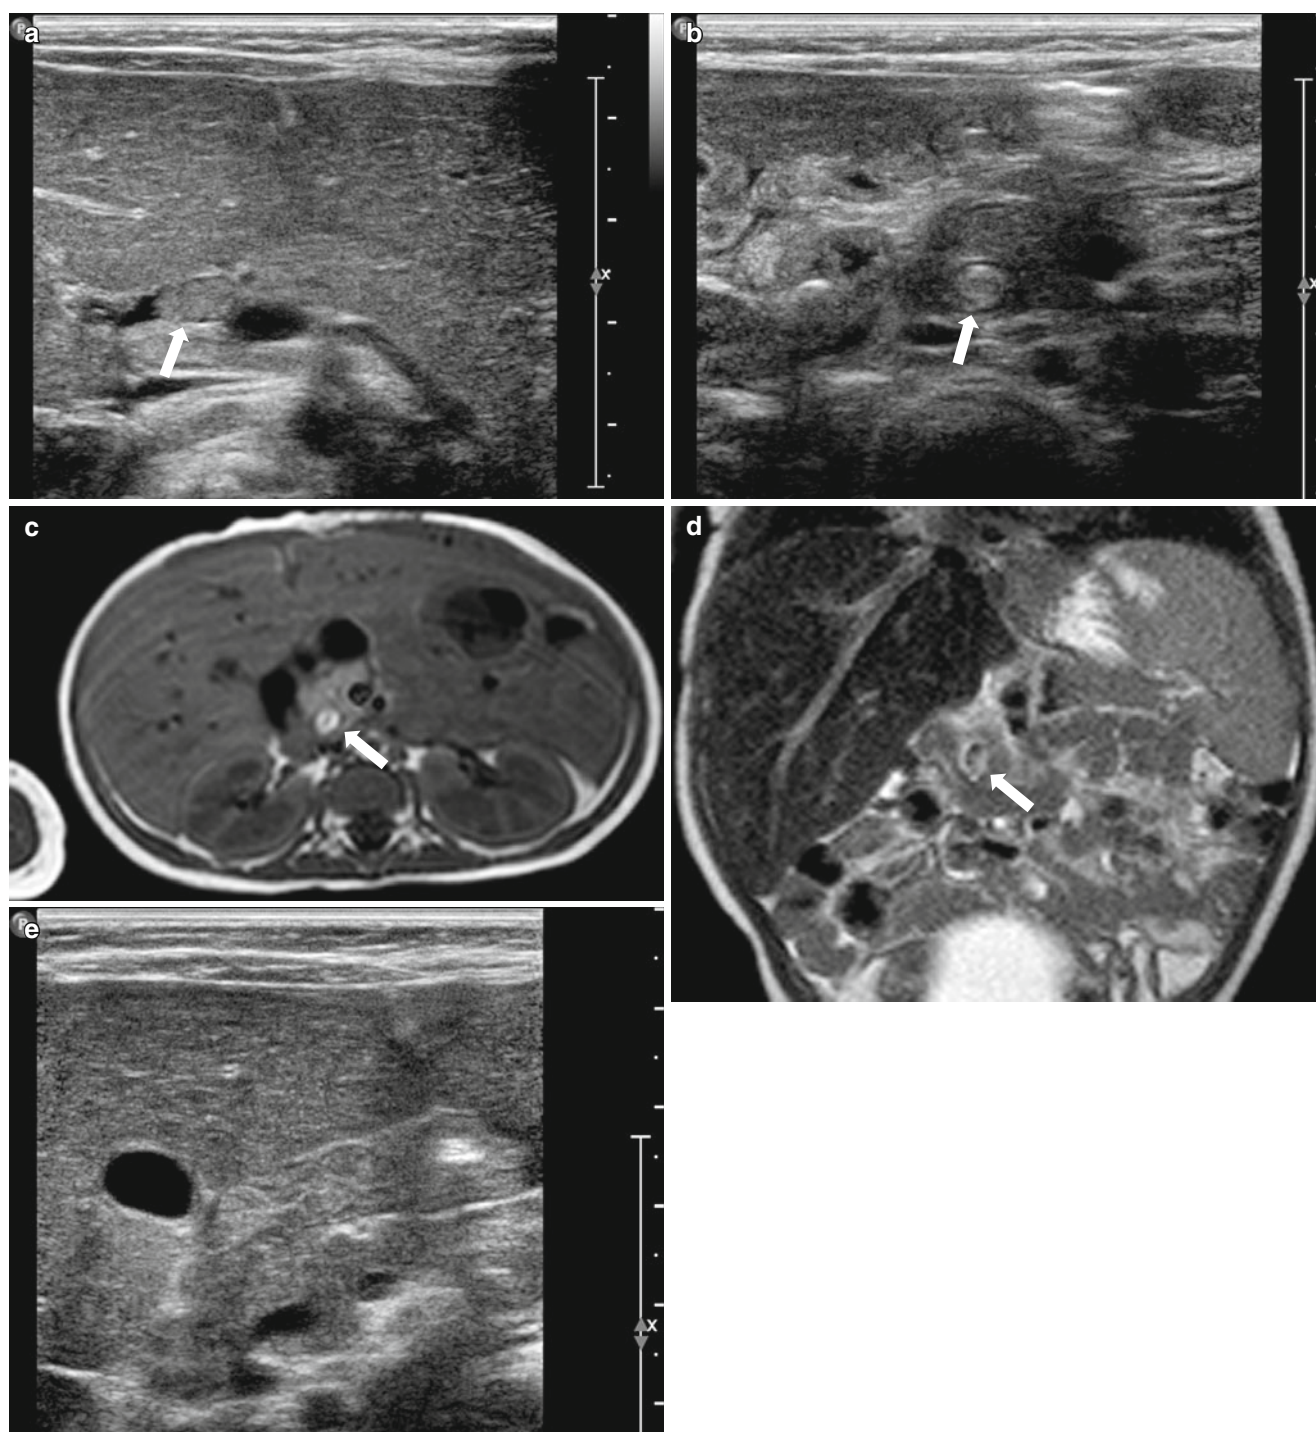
Bile-plug syndrome in a 3-month-old girl. (a and b) Abdominal US images show compact sludge (*arrows*) in common bile duct to pancreas head portion. (c) Axial T1-weighted MR image shows high-signal intensity sludge (*arrow*) in common bile duct. (d) The
